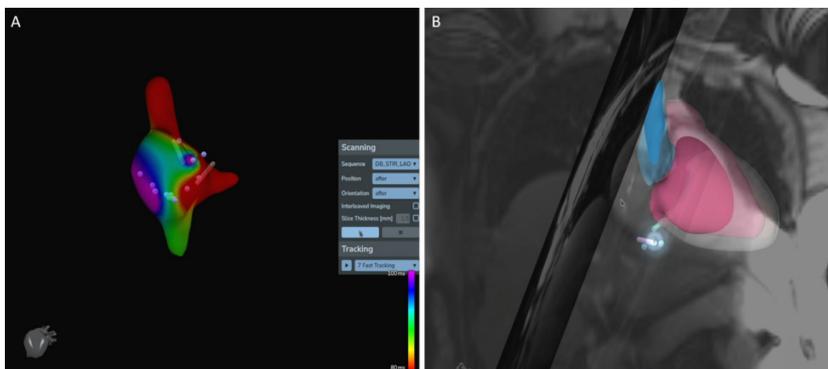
Electroanatomic mapping systems compatible for use inside a magnetic resonance scanner have been developed. A: 3D electroanatomical activation mapping; B: Integration with real-time cardiac magnetic resonance imaging planes. (Reproduced with permission from <https://imricor.com>).
